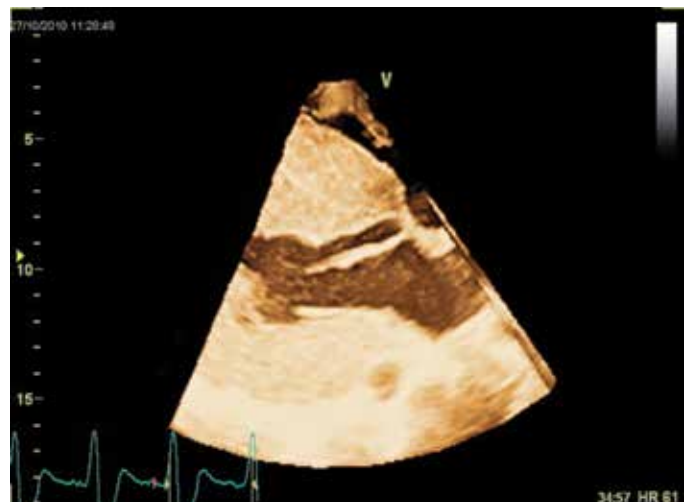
3D Echocardiographic view demonstrating impressive thickening of septum and posterior left ventricular wall.
